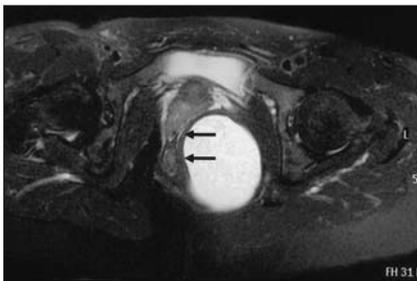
Axial T_2 -weighted magnetic resonance image of the pelvis showing the hyperintense unilocular cystic lesion in the left ischiorectal fossa with displacement of the vagina and the anal canal (arrows).
